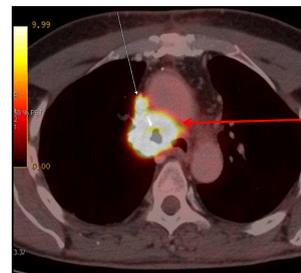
Re-assessment PETCT scan after 3 months of tablet Gefitinib showing the progression of the FDG avid right upper lobe perihilar lesion and mediastinal lymphadenopathy.
